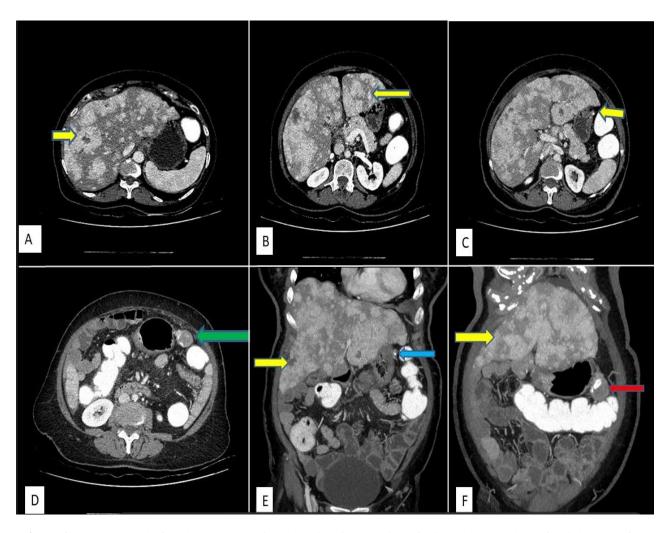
A 74-year-old female presented with yellowish discoloration of urine and sclera, loss of weight, loss of appetite and early satiety. CECT abdomen done. A&B) Axial CT images show multiple ill-defined arterially enhancing hypervascular lesions (yellow arrows) in the liver. C) Axial CT images show a small well defined heterogeneously enhancing lesion with a calcific focus (yellow arrow) involving the greater curvature of the stomach. D) Axial CT images show another similar lesion within the peritoneal cavity (green arrow) abutting the greater curvature of the stomach with few calcific specks. E) Coronal CT image show primary tumor involving the greater curvature of the stomach (blue arrow) and diffuse hepatic metastasis (yellow arrow). F) Coronal CT image show lesion within the peritoneal cavity (red arrow) and diffuse hepatic metastases (yellow arrow).
